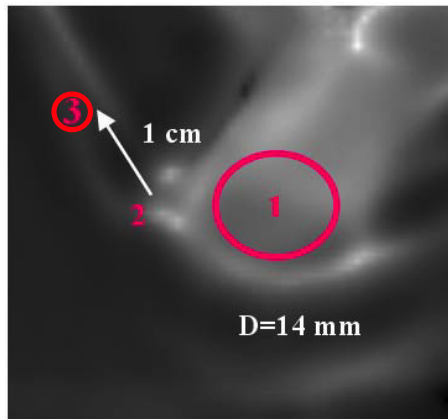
ROIs selection for ultrasound measurements of (1) calcaneus, (2) Achilles tendon–calcaneus insertion and (3) Achilles tendon.
